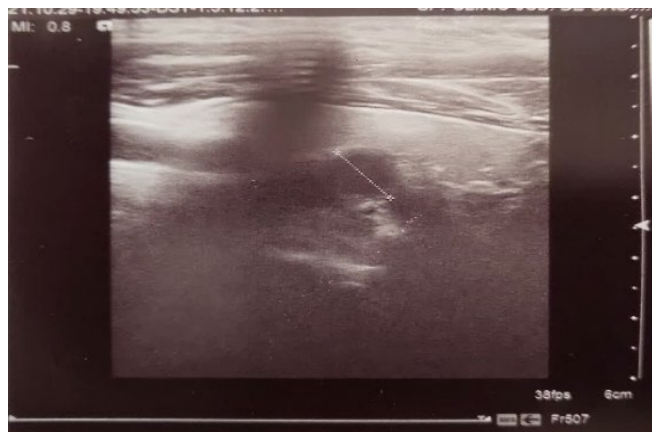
Cervical ultrasound (initial evaluation): intensely hypoechoic image in the posterior area of the left thyroid lobe, with 1 cm diameter, with a large posterior shadow (possibly the parathyroid gland with completely calcified periphery)
